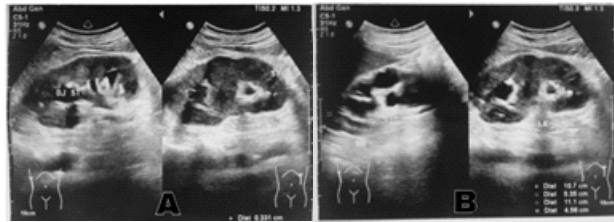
Ultrasonography Examination, (A) Right Kidney: the picture of right kidney shows kidney stone on the upper pole, DJ Stent intrarenal and mild ectasis of Kidney. (B) Left Kidney: the picture show the left kidney with moderate ectasis.
